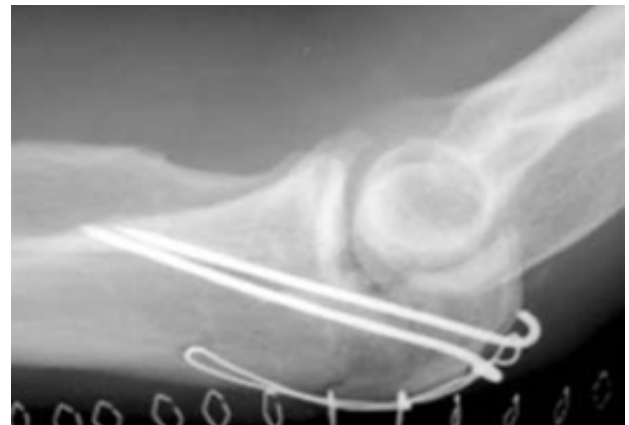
Radiograph after Union
